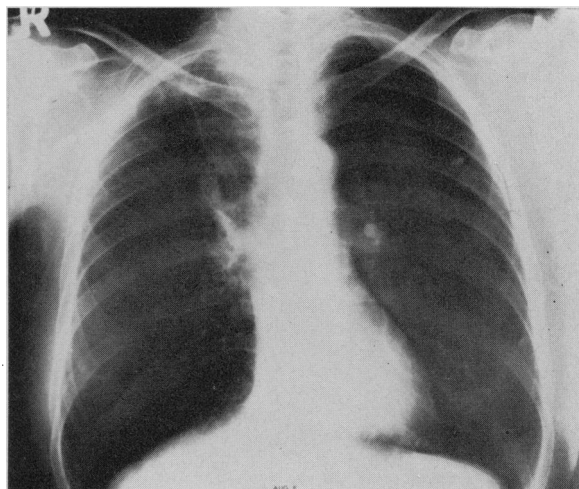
Radiograph taken on August 8 showing dramatic improvement following the initial course of methotrexate.
